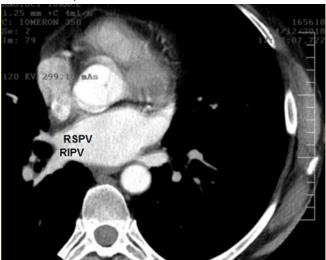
Computed tomography of the heart. Right veins can be differentiated by their orientation: RSPV has an anterior orientation, RIPV has a posterior orientation.
